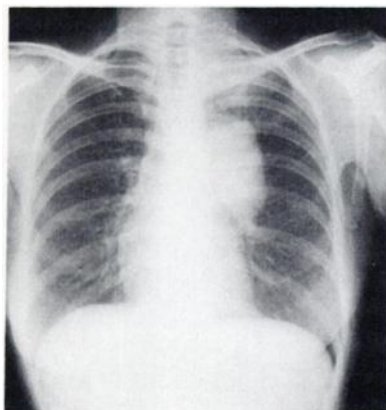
Chest radiograph taken at admission shows large left hilar mass.
